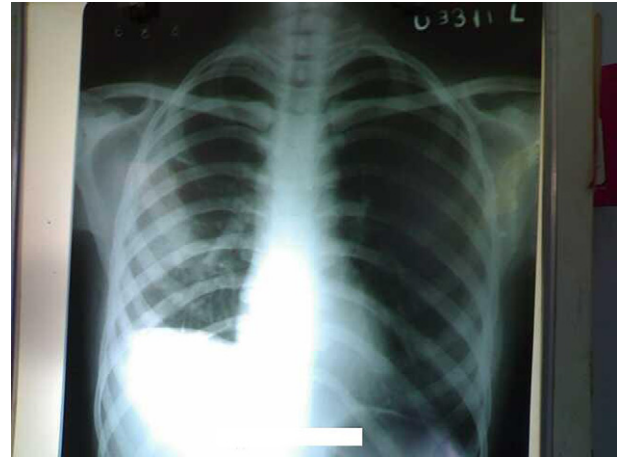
Chest X-ray PA view shows radiological clearing.
